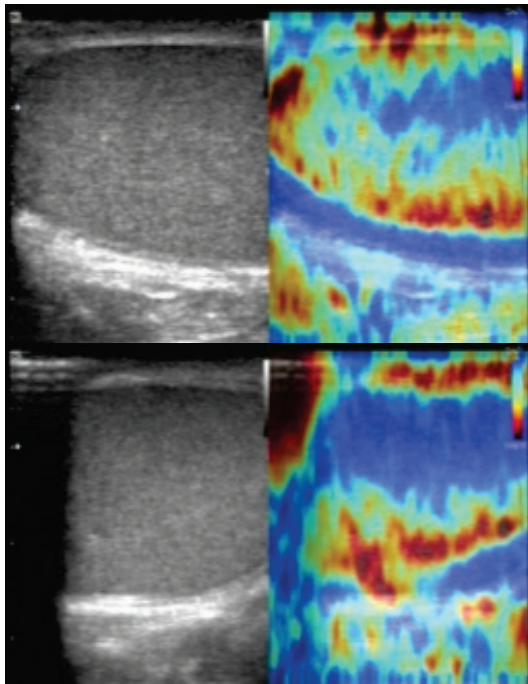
Ultrasound examination with dopplerography and elastography of the right and left testicles of a patient with non-obstructive form of azoospermia
